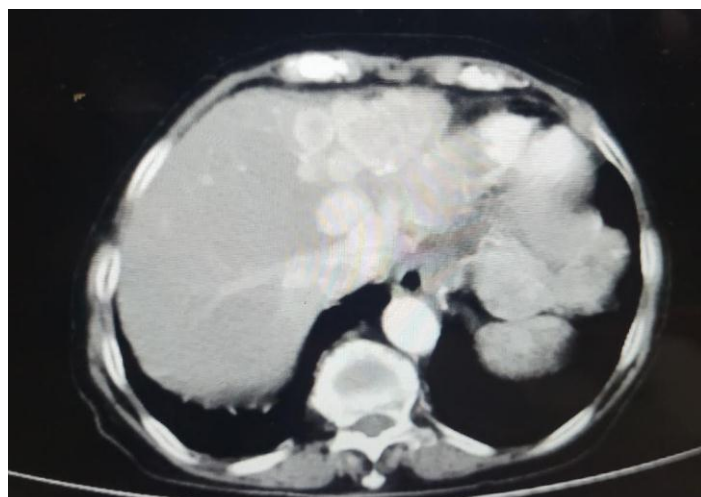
CT Abdomen showed large heterogenous enhancing mass with lobular surface replacing the left lobe of liver.
